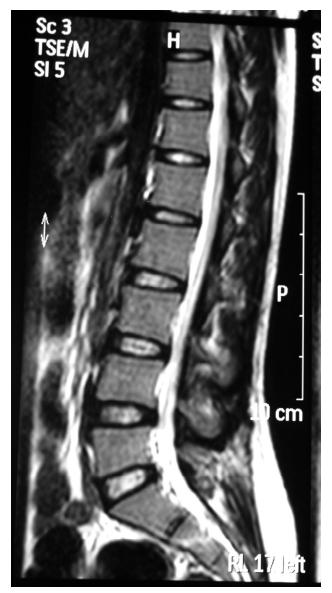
MRI showing complete resolution after 12 months of chemotherapy.
